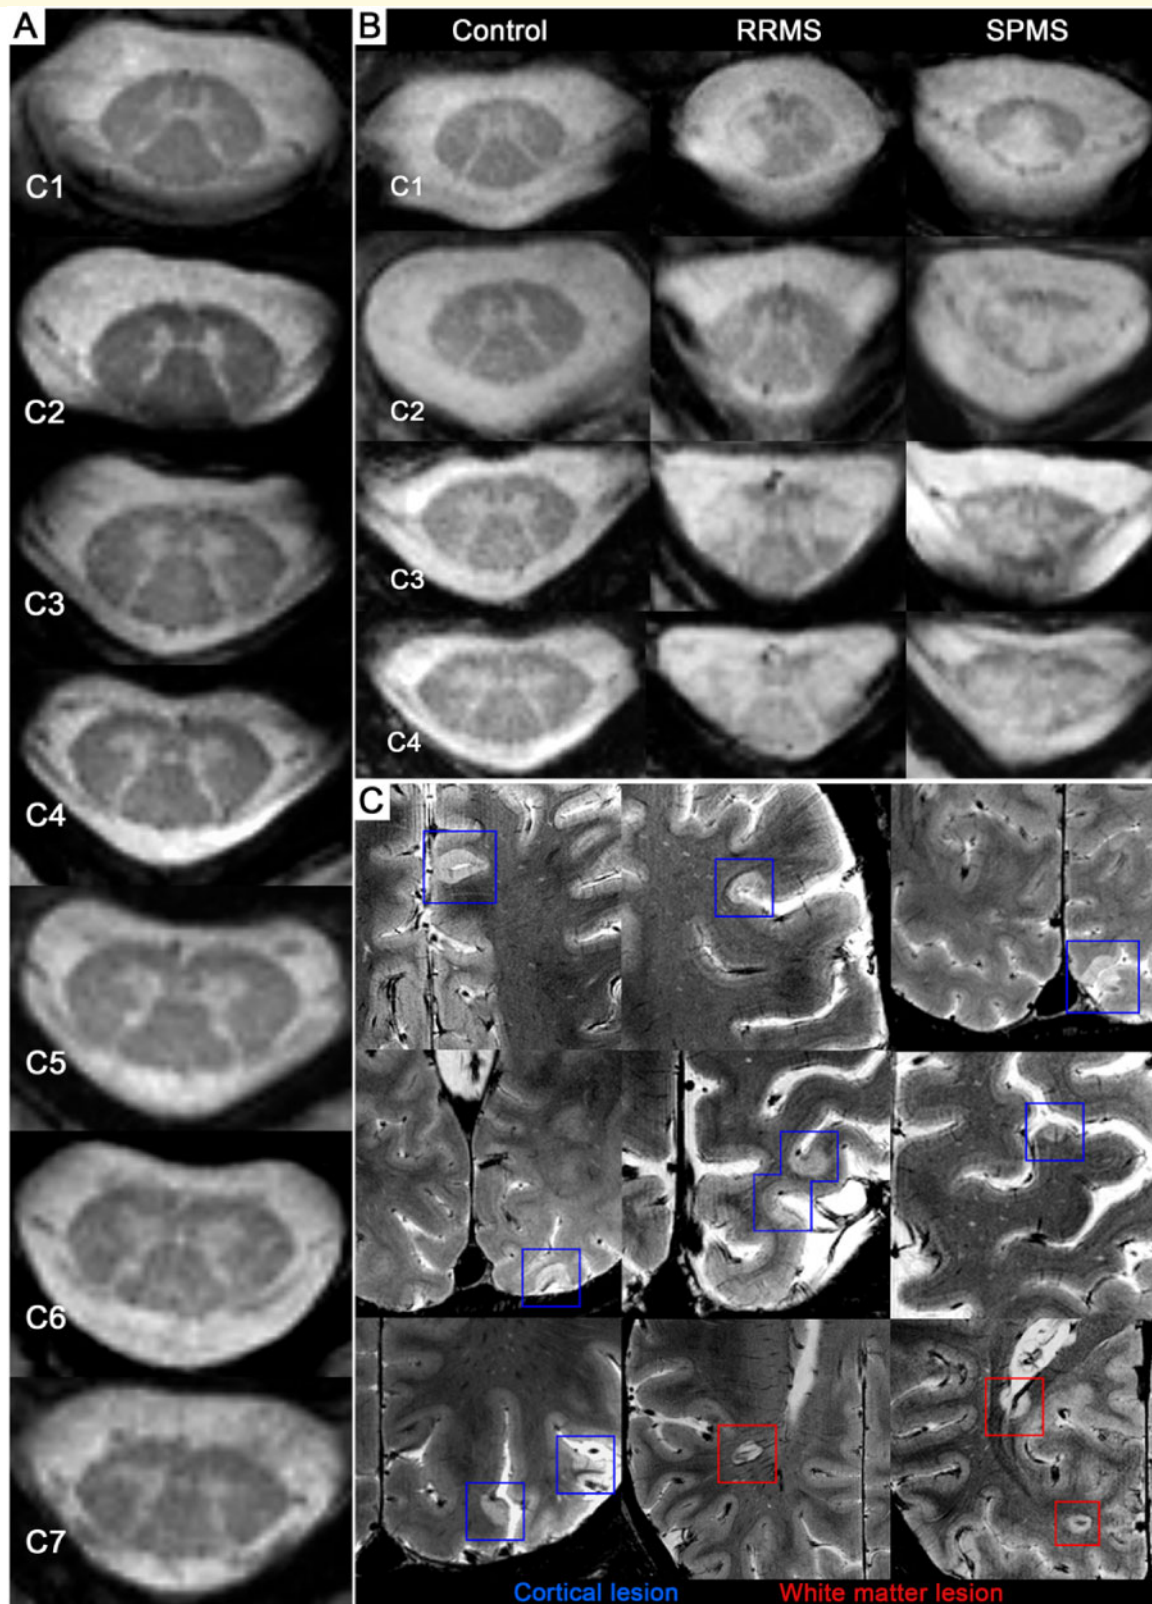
Ultra-high field strength MRI detection of cervical spinal cord and brain lesions. (A) Full coverage of the cervical spinal cord (C1–C7) in a 40-year-old female RRMS participant, disease duration of 3 years and an EDSS score of 2. (B) Cervical levels (C1–C4, from left to right) in a 42-year-old female healthy volunteer, 45-year-old male RRMS participant (disease duration: 4 years, EDSS: 2) and 36-year-old male SPMS participant (disease duration: 20 years, EDSS: 6.5). (C) Cortical (blue) and white matter (red) lesions shown in the same 45-year-old male RRMS participant.
